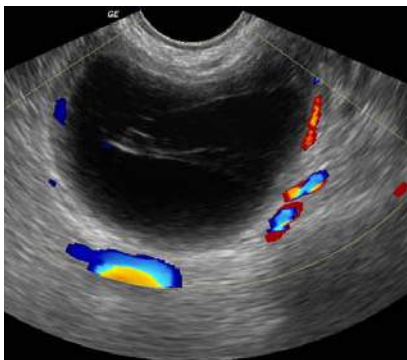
Transvaginal color doppler scan, same patient showing pericystic flow
